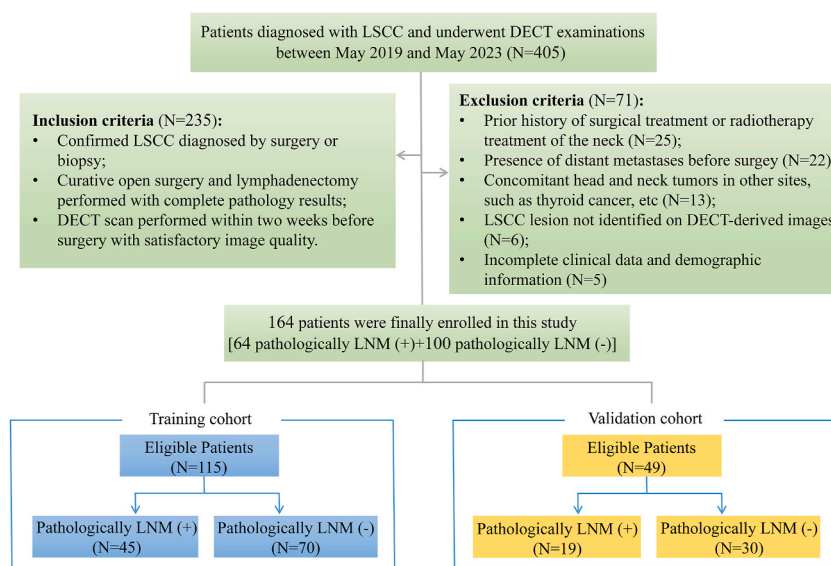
Patient screening procedure. DECT, dual-energy computed tomography; LNM, lymph node metastasis; LSCC, laryngeal squamous cell carcinoma.
